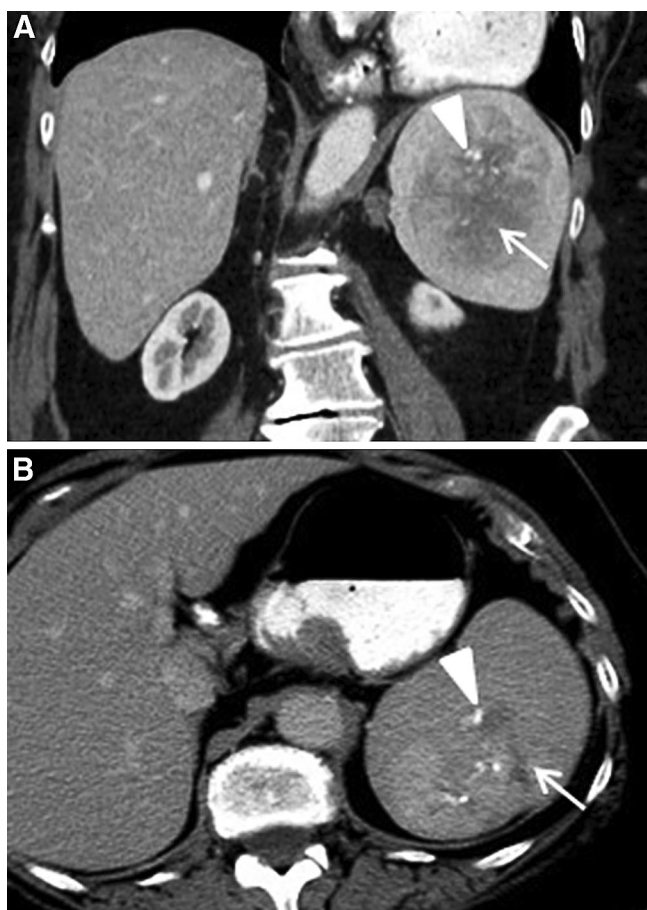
Splenic leiomyosarcoma. 44-year-old man with left upper quadrant pain A coronal reformat and B axial contrast-enhanced CT images demonstrate a large, heterogeneous mass in the spleen with internal low-attenuation areas (arrows, representing necrosis and/or hemorrhage) and several internal calcifications (arrowheads). The mass does not extend through the splenic capsule. Splenectomy was performed, and the pathology showed leiomyosarcoma.
